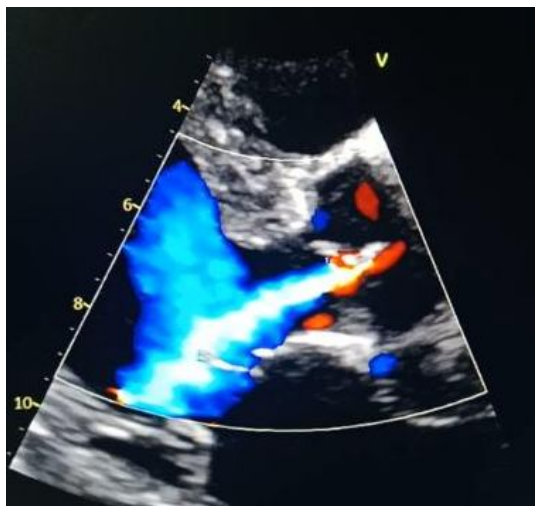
Transthoracic echocardiography (TTE) shows a moderate aortic regurgitation, Vena contracta:4mm.
